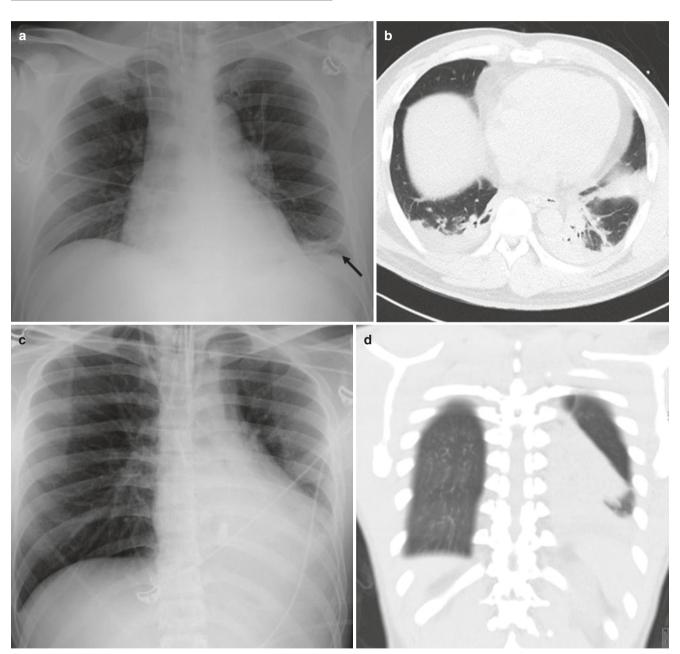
Atelectasis. (a) AP chest radiograph of a postoperative patient demonstrates band-like opacity in the left lower zone. (b) Corresponding axial CT image in lung window demonstrates bilateral lower lobe densities with crowding of airways and wedgeshaped opacity in the lingula. (c) AP chest radiograph in another
